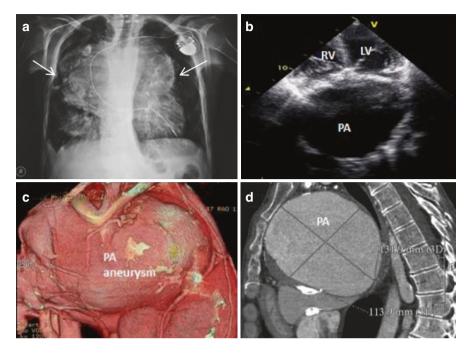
Complex congenital heart disease associated with Eisenmenger syndrome. This is a 37-year-old male with transposition of the great arteries and large ventricular septal defect, who had undergone a palliative Mustard procedure and subsequently insertion of a pacemaker. When he was referred to a specialized PAH-CHD center, he was found to have a giant pulmonary artery aneurysm on the chest radiogram (a, arrows), echocardiography study (b), and cardiac computed tomography (c and d). *PA* pulmonary artery, *LV* left ventricle, *RV* right ventricle
